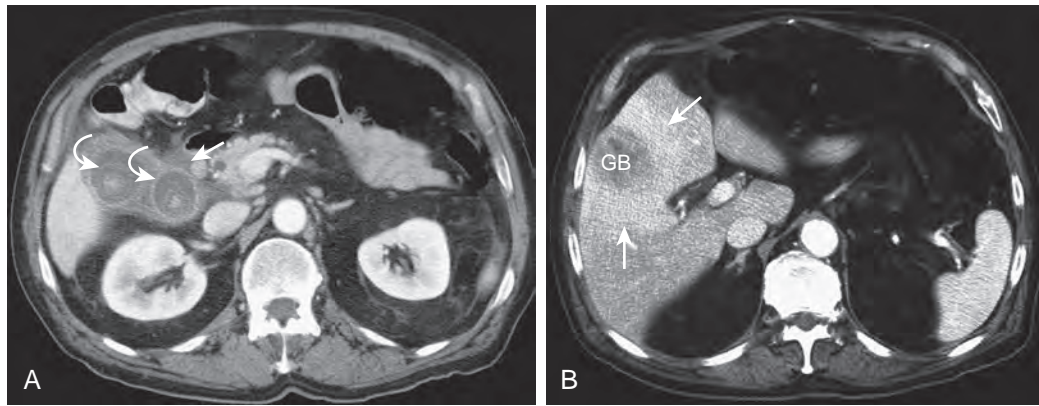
Acute cholecystitis: CT features. A. Two large stones (curved arrows) are identified within a thick-walled gallbladder. Notice the pericholecystic fluid (straight arrow). B. The more cephalad scan, displayed with a narrow window, shows a region of transient hepatic attenuation difference (arrows) surrounding the inflamed gallbladder (GB).
